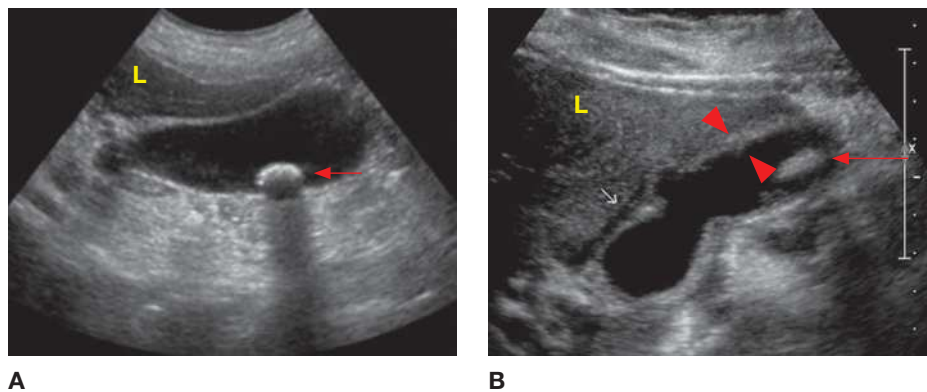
Gallstone disease. (A) Cholelithiasis. Ultrasound image of the gallbladder shows a gallstone (arrow) with posterior shadowing. (B) Acute cholecystitis. Ultrasound image shows a gallstone (red arrow), a thickened gallbladder wall (arrowheads), and pericholecystic fluid (white arrow). L, liver. (Reproduced with permission from USMLE-Rx.com.)
